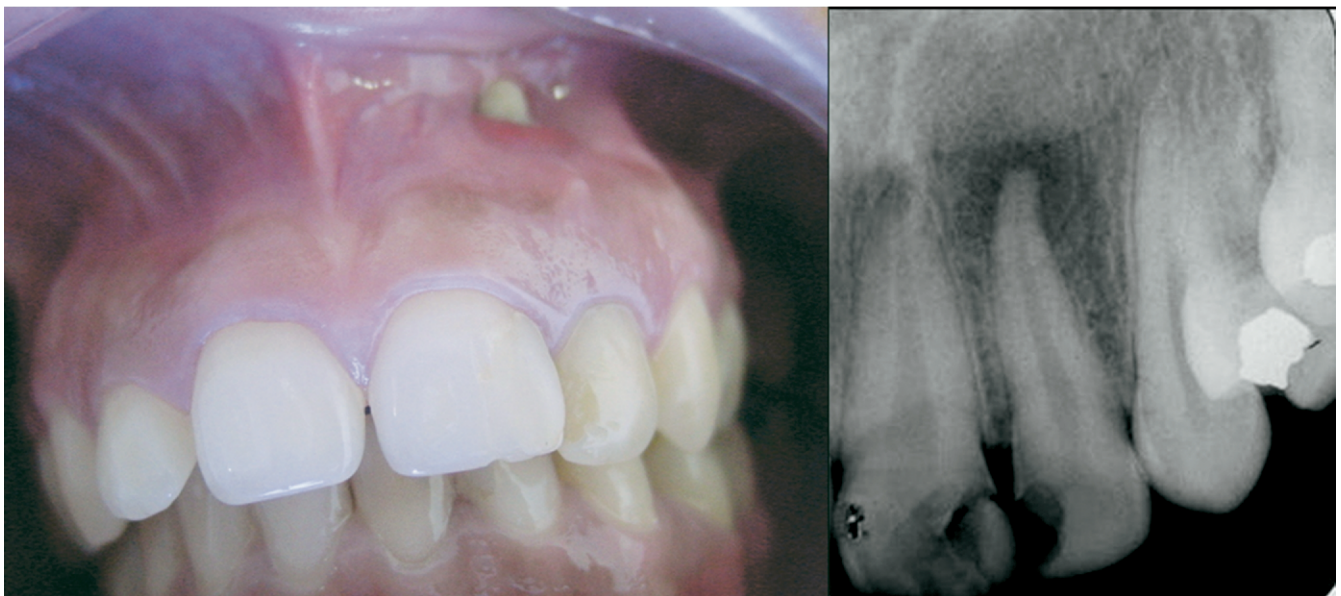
Exposed apical root third observed during clinical examination, and periapical radiograph showing a large radiolucent area surrounding the tooth apex.
